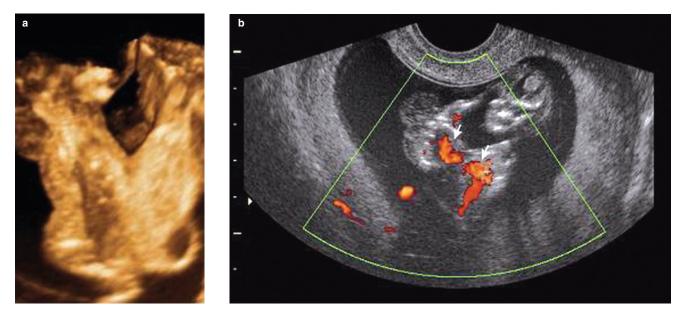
(a) Three-dimensional ultrasound image showing thoracopagus twins. (b) Doppler ultrasound image showing thoracopagus twins. Two hearts are depicted by the Doppler scan (arrows). Images courtesy of Y. Hazan, Kaplan Medical Center, Israel
